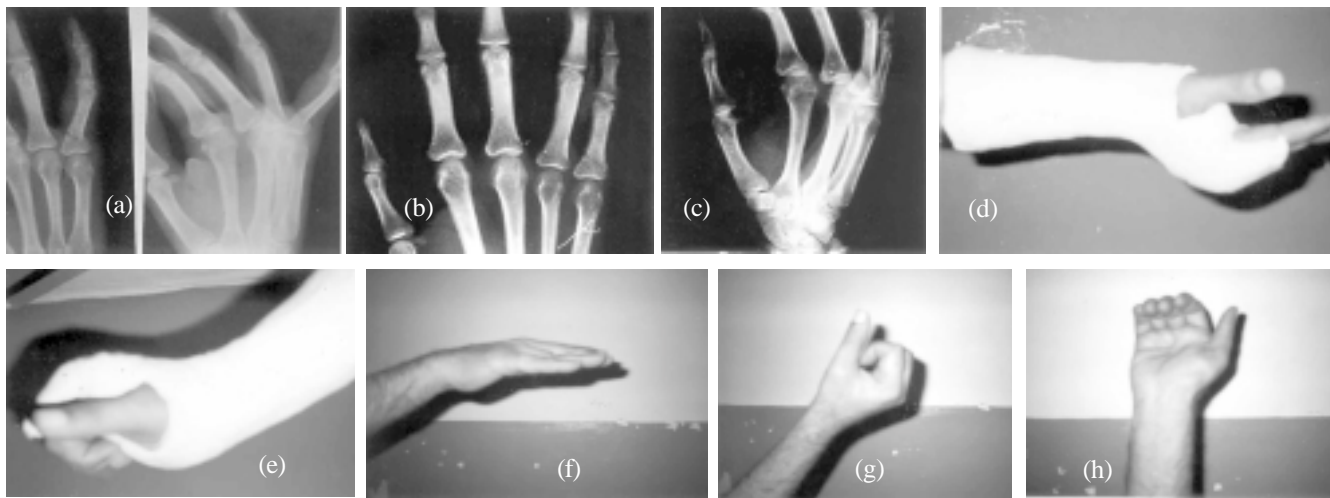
Fracture of proximal phalanx base of little finger with typical volar angulation. b. Check AP radiograph showing the fracture in good alignment after 3 weeks of treatment in dorsal extension block cast. c. Check lateral radiograph after 3 weeks showing the PP of LF in good alignment with no angulations. d. Full extension in dorsal extension block cast. e. Full flexion achieved in the cast. f. Full extension of the hand with no extension lag after 3 weeks in cast. g. Clinical Photograph Full flexion of hand after 3 weeks in cast. h. there is no apparent rotational or angulatory deformity of LF after 3 weeks of cast.
